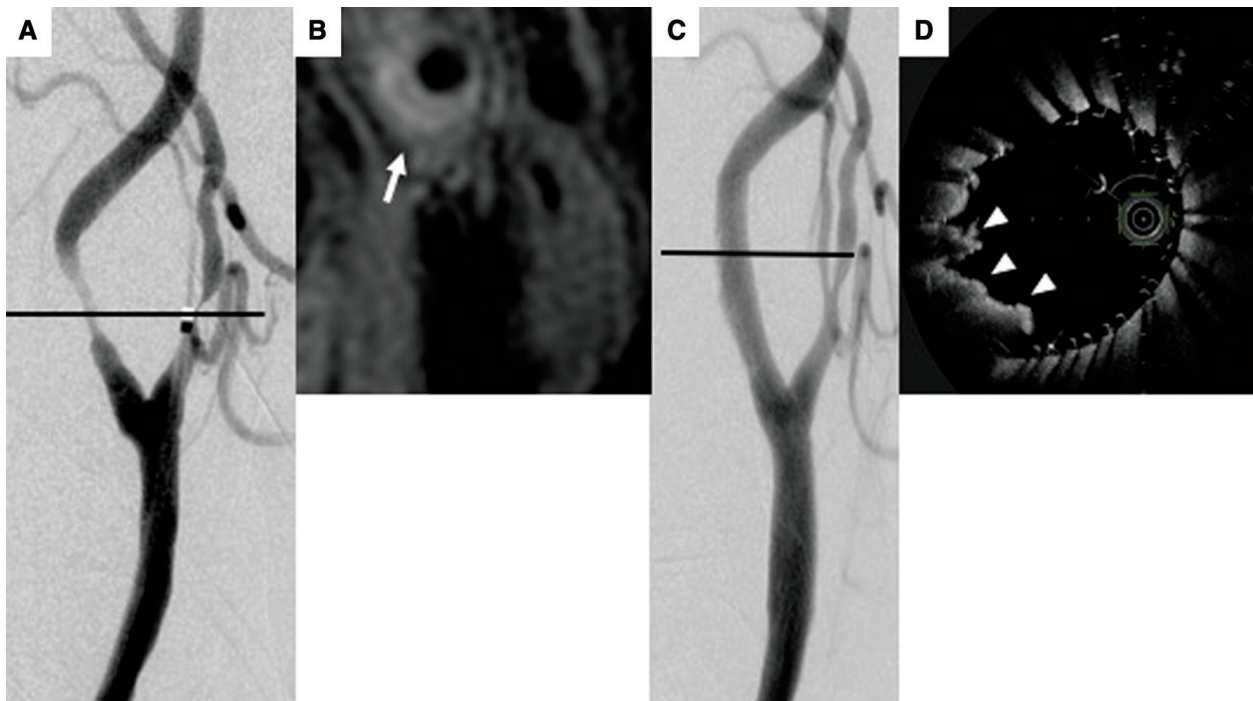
Representative images positive for PP. A case of symptomatic left carotid artery stenosis and unstable plaques treated with a conventional stent. (Moderated and cited from Yamada et al.²²) with permission from Elsevier (A) Digital-subtraction angiography before CAS. (B) T1-weighted MRI of carotid plaque indicated an unstable plaque (signal intensity ratio compared with adjacent muscle was 1.66: white arrow). (C) DSA after CAS. The stenotic lesion was successfully dilated. (D) OFDI after CAS showed large PP. CAS: carotid artery stenting; DSA: digital-subtraction angiography; OFDI: optical frequency domain imaging; PP: plaque protrusion
